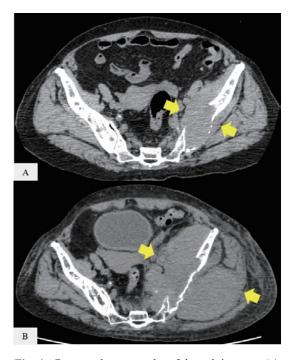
Computed tomography of the pelvic tumor (A, at diagnosis; B; after BD therapy).
